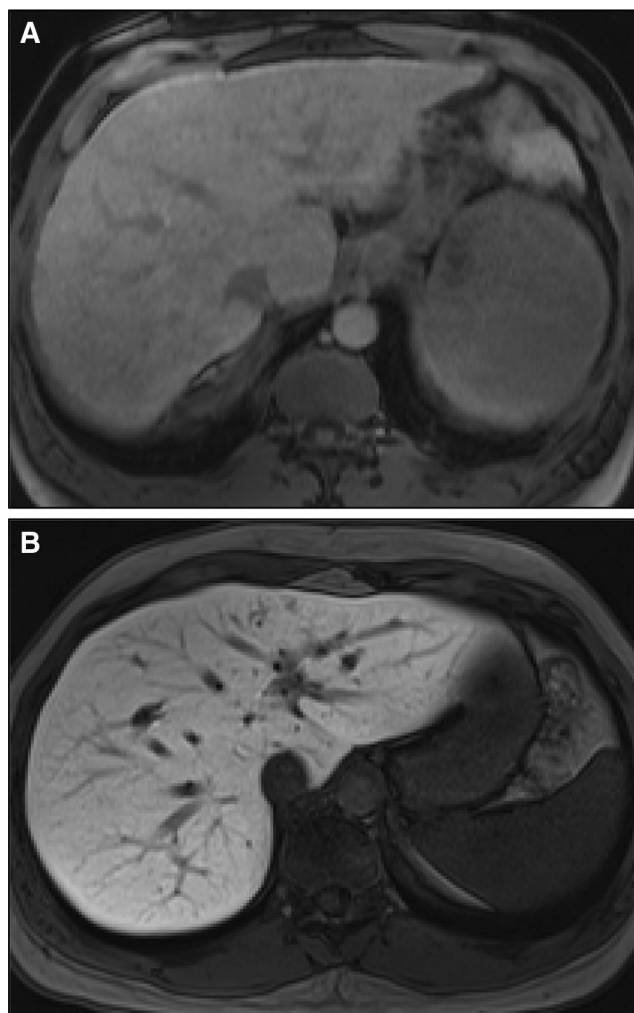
A, B MRI using hepatobiliary contrast shows that on the hepatocyte phase, there is decreased liver enhancement of a cirrhotic liver (A) compared with a noncirrhotic liver (B).
